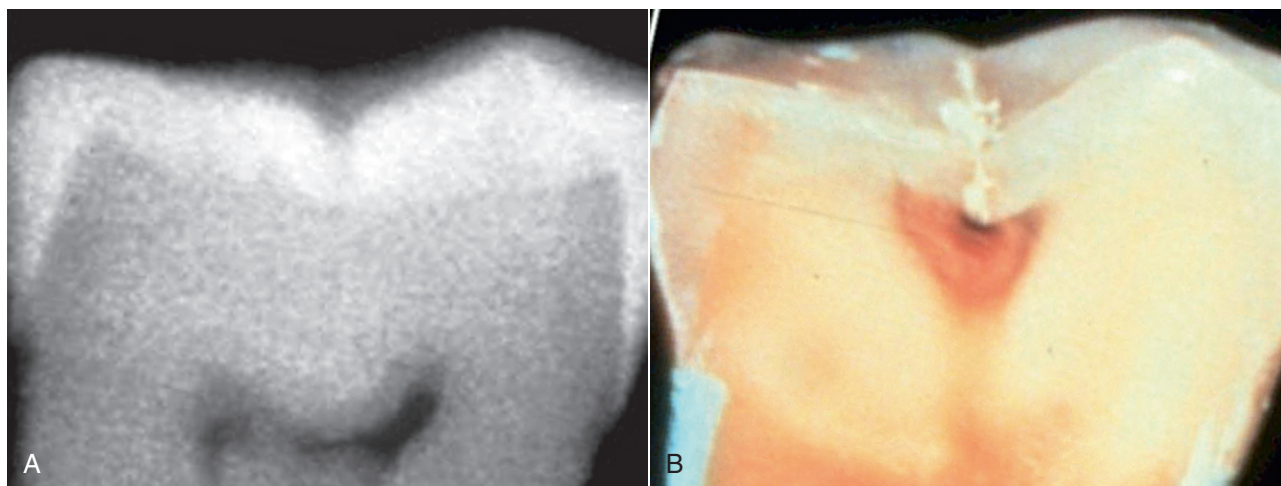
A, Radiograph showing an apparently healthy tooth. B, Cross-section of tooth showing hidden caries spreading along the dentino-enamel junction.
